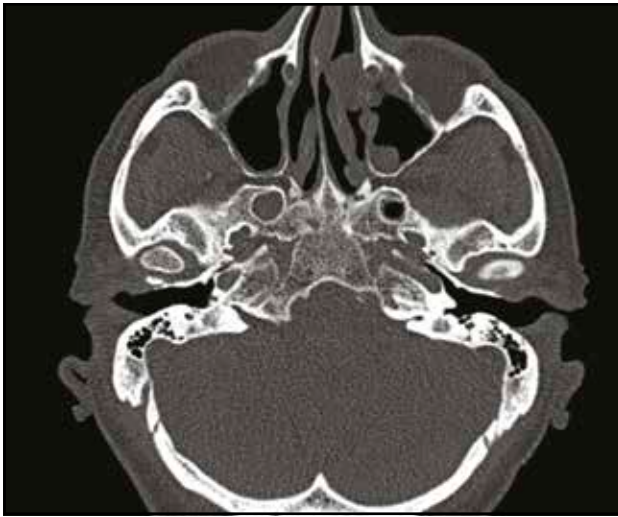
Axial craniofacial CT scan image showing a mass in the left nasal cavity.
